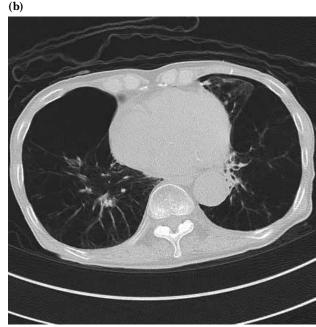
Radiographic imaging of chest on admission of Case 1, revealing left pneumothorax (a) and pulmonary emphysema on the chest CT (b).
